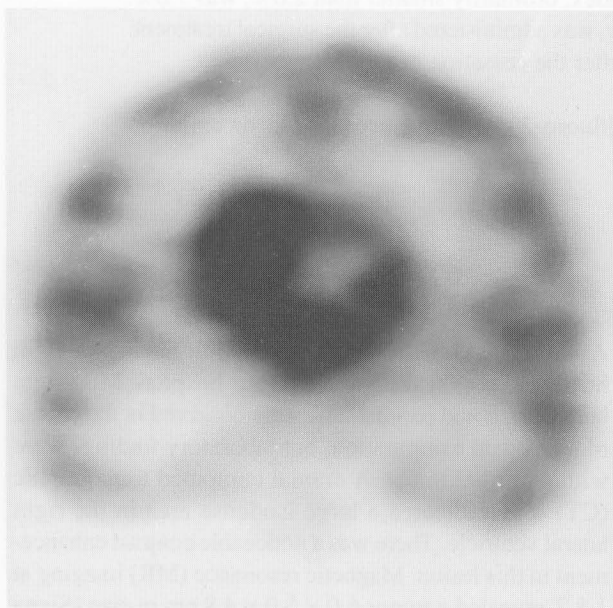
The coronal image of FDG PET scan before surgery showing intense FDG uptake by the tumor with a standardized uptake value (SUV) of 13.27 (compared with SUV of 7.00 in the normal cortex).
